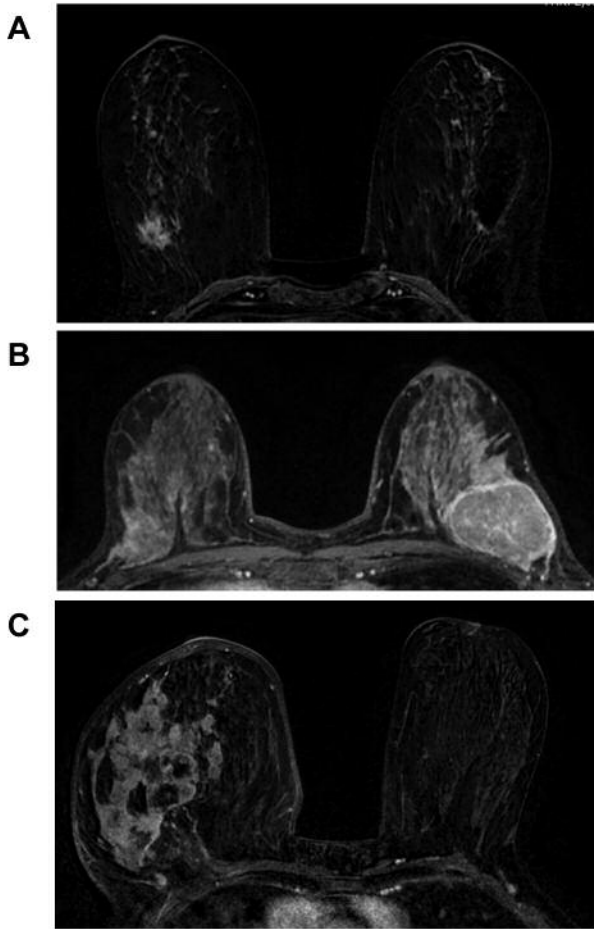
Breast cancer MRI appearances. A: Luminal A/B tumor: mass with irregular margins. B: HER2+ tumor: mass with regular margins. C: Triple negative tumor: mass with intra-tumoral necrosis.
